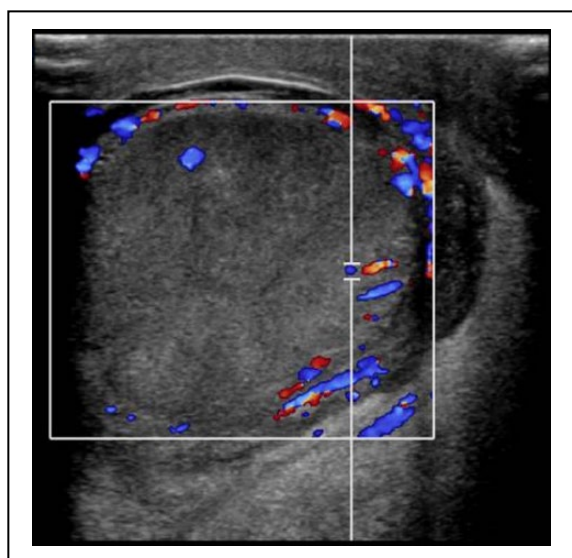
(a). Preoperative ultrasound of a boy patient's affected left testis, showing a heterogenous appearance and reduced central vascularity.
